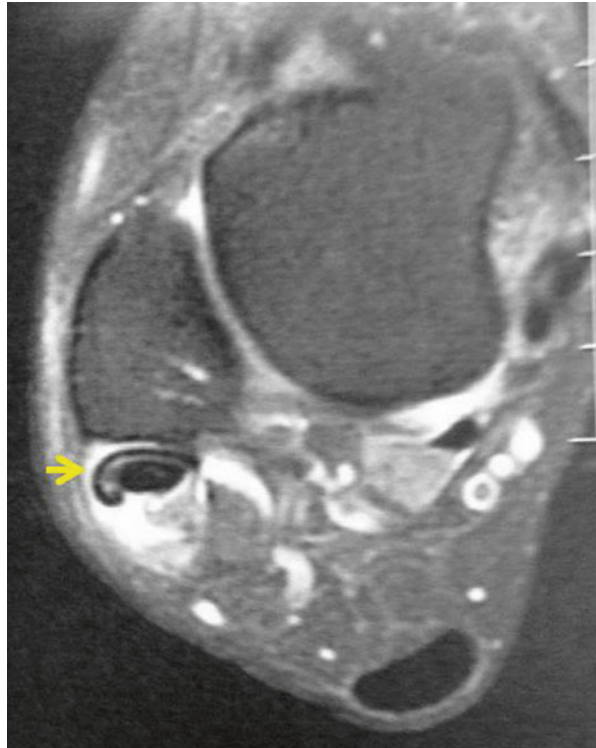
MRI showing peroneus brevis tendinopathy (yellow arrow). Notice flattening of the ruptured tendon surrounding peroneus longus and increased fluid within the synovial sheath surrounding both tendons
